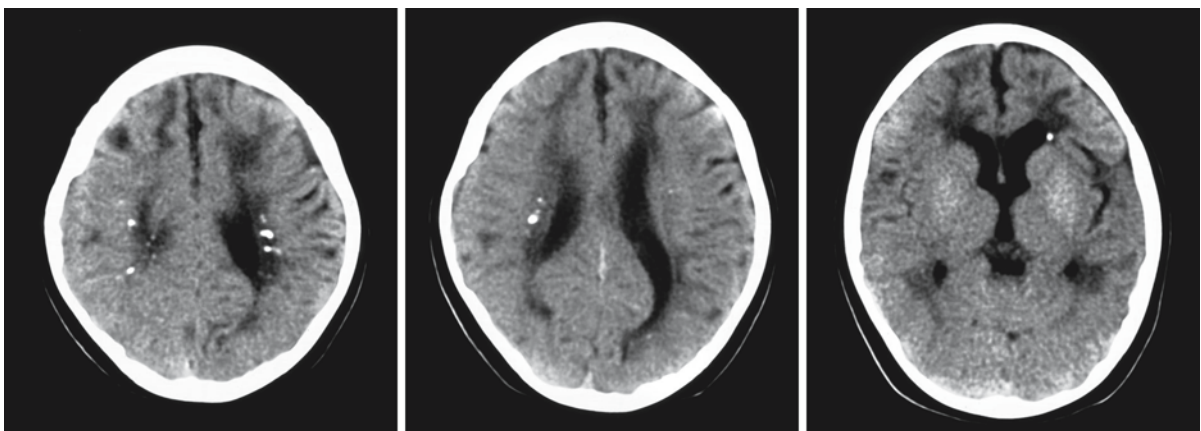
CT of a 3-year-old severely affected patient with Aicardi–Goutières syndrome. There are calcium deposits in the basal ganglia and periventricular white matter. The calcium
